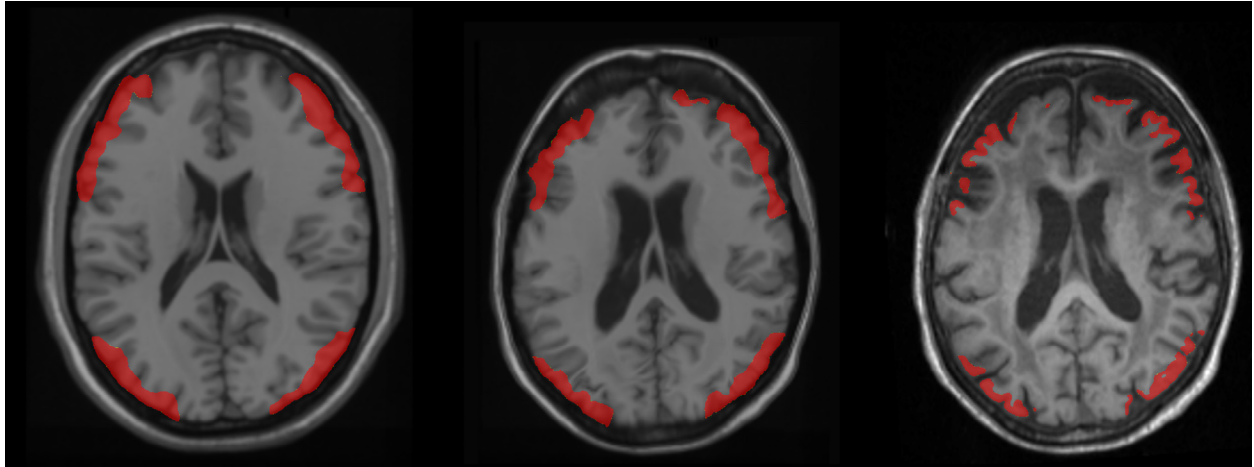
Example of automated registration of common space atlas and automated VOI generation in subject space. (Left) Common space MRI with VOIs for posterior frontal lobe and occipital-parietal regions. (Center) Common space MRI and VOIs warped to subject space. (Right) Subject MRI with automatically generated VOIs composed with grey-matter segmentation.
